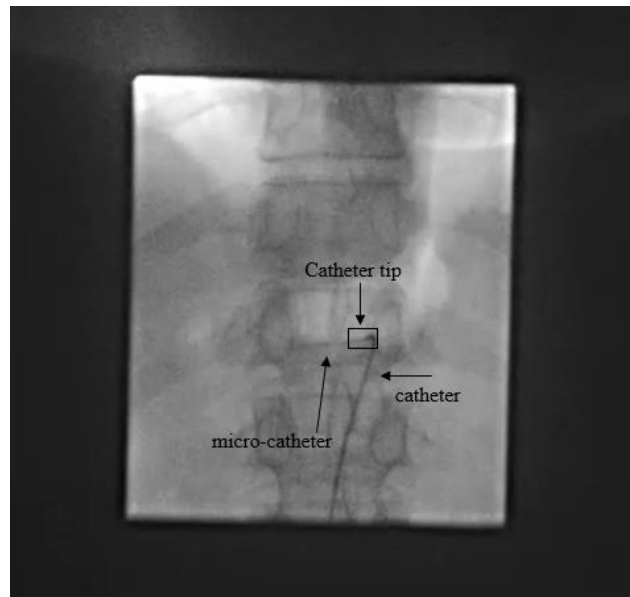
X-Ray fluoroscopy visualizing the guiding catheter in radioembolization
